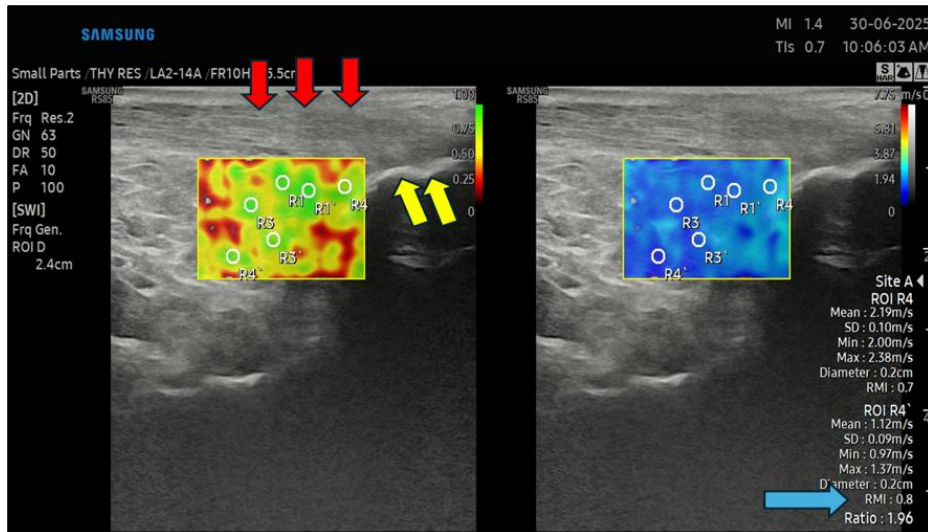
2D-shear wave elastography (2D-SWE) image of the right Kager's fat pad (KFP), Achilles tendon (AT) (red arrows) and Calcaneus bone (yellow arrows) in a longitudinal scanning plane. The region of interest (ROI) in the SWE image is represented by the white circle, which is set to a size of 1 mm. This ROI is used to measure the stiffness of the KFP within the selected area. A single layer of ultrasound gel was used for optimal contact. The color scale represents tissue stiffness, with green indicating areas of lower stiffness and yellow indicating areas of higher stiffness, measured in meters per second (m/s).
